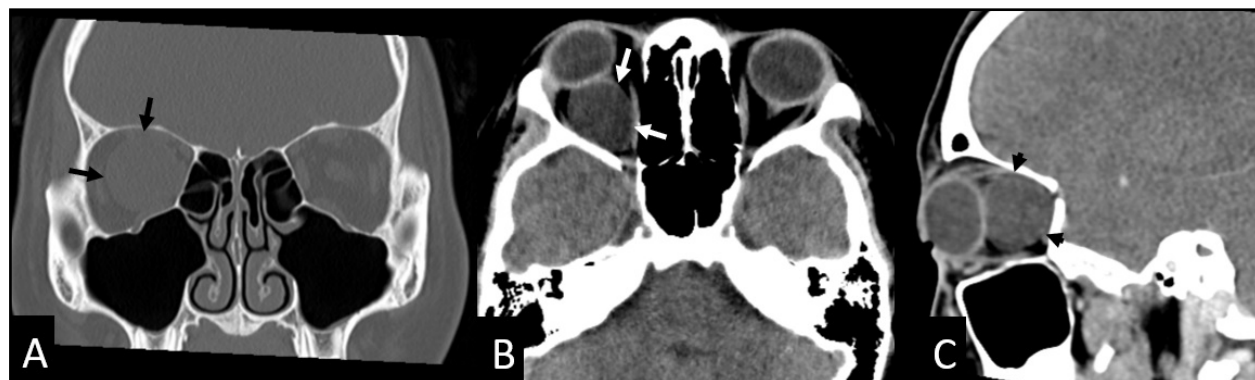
CT: well-defined intraconal cystic mass without bone compromise (black arrows); homogeneous hypodense mass with evidence of extraocular muscle displacement (white arrows), without enhancement after intravenous contrast injection (black arrowheads) A. bone window, B. soft tissues window, C. soft tissues window+contrast.
